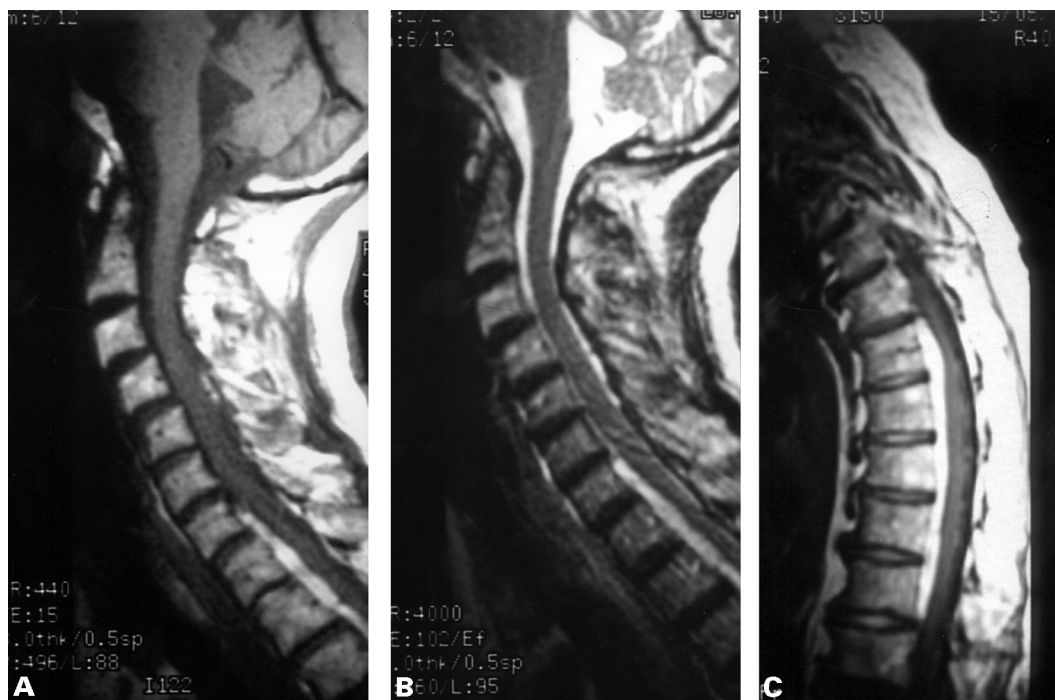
Figure MRI images of the spine. (A) Sagittal T1-weighted image of the cervical spine (TR 440 ms, TE 15 ms), (B) sagittal T2-weighted image of the cervical spine (TR 4000 ms, TE 102 ms); (C) sagittal T1-weighted image of the dorsal spine (TR 440 ms, TE 15 ms)
